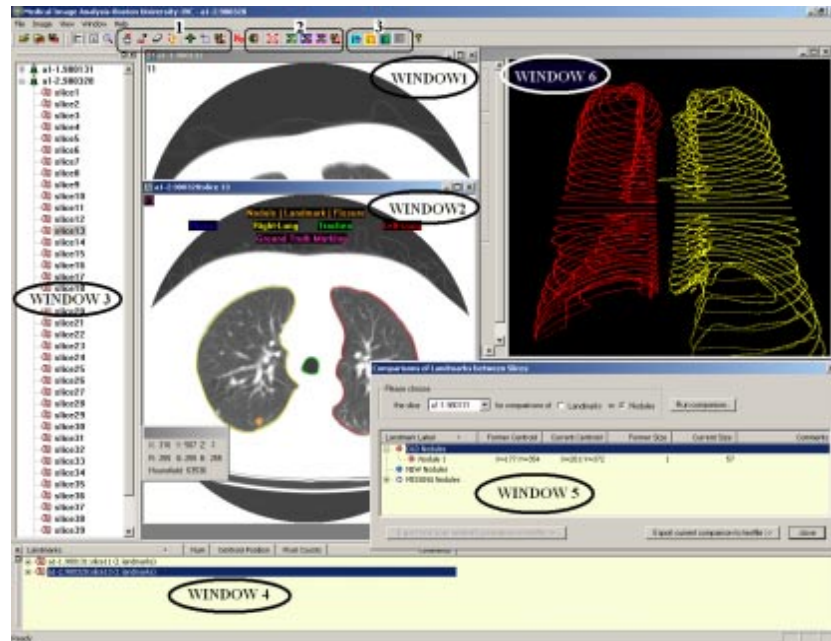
The BU-MIA interface: Windows 1 and 2 contain axial images of two CT chest studies of the same patient scanned at different time. Users can browse through each study slice by slice (Window 3). Window 4 tabulates landmark information included in the current slice. Window 5 compares information on corresponding landmarks (e.g. nodules) computed from selected images. In Window 6, a 3D lung surface is rendered based on segmented lung contours. The buttons on the top toolbar are used to select various system functionalities: (1) interaction tools like marking various lung structures or editing the marking regions, (2) image analysis programs, e.g. chest, lung, or fissure segmentation, and (3) visualization tools to view various image analysis results.
